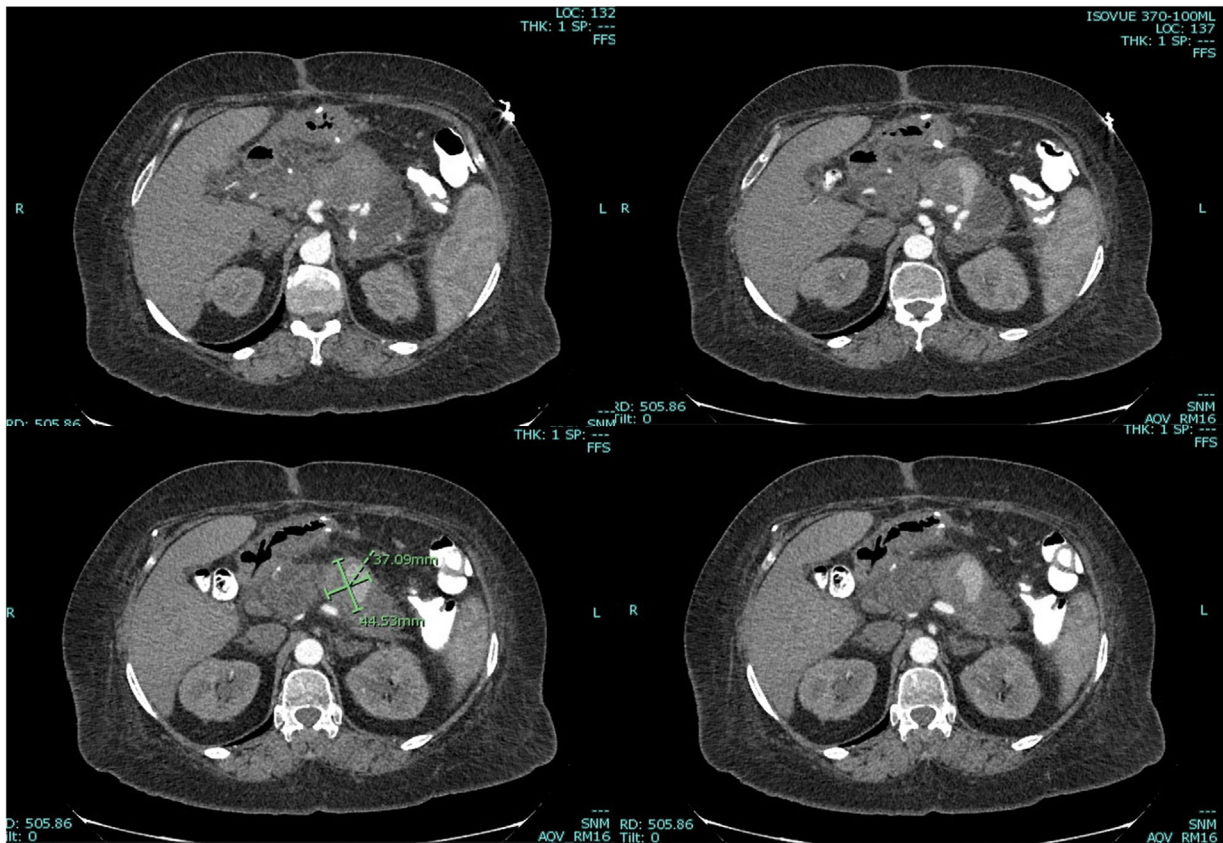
Preoperative computed tomography (CT) angiogram showing splenic artery pseudoaneurysm and pseudocyst.
